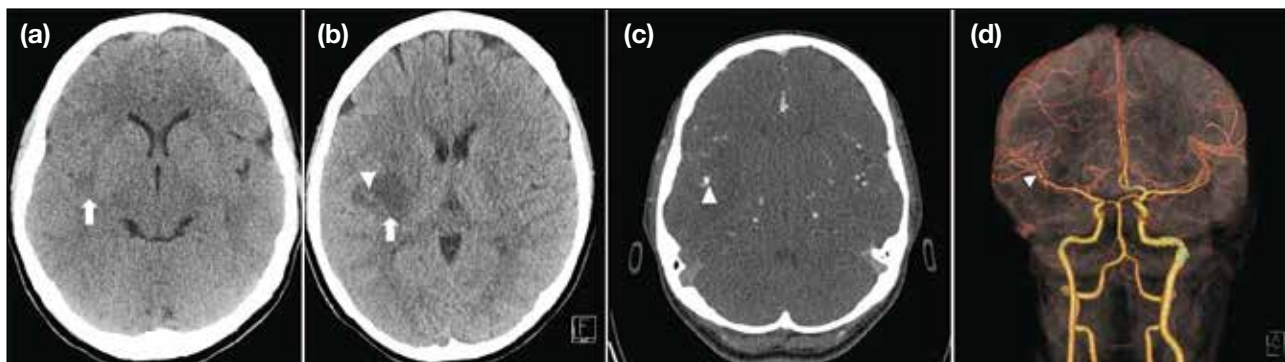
A 27-year-old woman presented with fever, left-sided weakness, and slurred speech. (a) Initial axial non-contrast computed tomography (CT) of the brain shows a small focus of hypodensity in the right temporoparietal region (arrow). (b) Follow-up axial non-contrast CT 1 day later demonstrates rapid enlargement of the hypodensity in the right temporoparietal region (arrow), with a small acute haemorrhagic focus (arrowhead). (c) Axial computed tomography angiography (CTA) shows a small contrast-enhancing focus at the proximal M2 segment of the right middle cerebral artery (arrowhead) within the infarct, suggestive of an aneurysm. (d) Volumetric rendering of the CTA shows the saccular morphology of the proximal right M2 aneurysm (arrowhead), consistent with a mycotic aneurysm.
